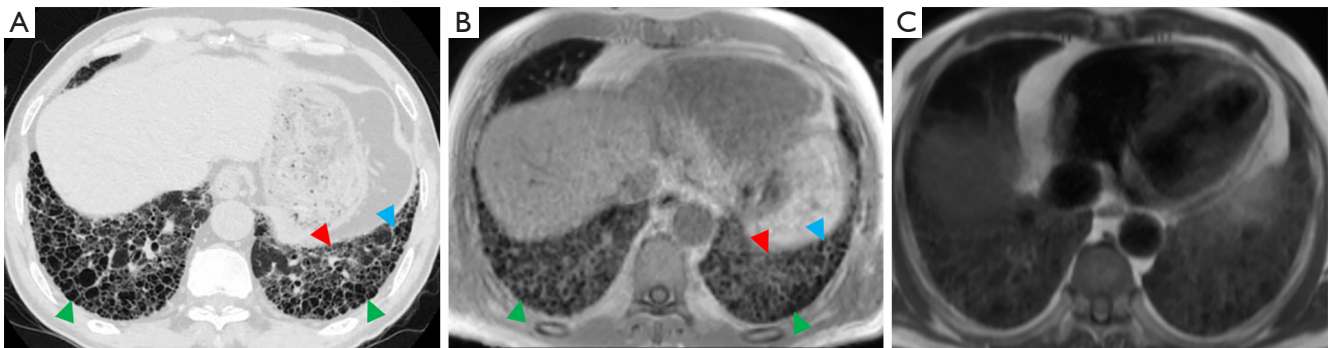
A 77-year-old male patient with interstitial pulmonary fibrosis. Images were obtained with HRCT (A), 3D UTE-MRI (B), and HASTE (C). Honeycombing (green arrow), reticular patterns (red arrow), and traction bronchiectasis (blue arrow) are seen in the left and/or right lower lobes. 3D UTE-MRI and HRCT image qualities are equal (IQS: 5), which were higher than the HASTE image quality (IQS: 4). The extent of pulmonary fibrosis on images obtained with 3D UTE-MRI (IQS: 16) was equal to those obtained with HRCT (IQS: 16). The transverse 3D UTE-MRI images are MPRs. HRCT, high-resolution computed tomography; 3D UTE-MRI, 3D ultrashort echo time magnetic resonance imaging; HASTE, half-Fourier single-shot turbo spin-echo; MPRs, multiplanar reconstructions; IQS, image quality score.
